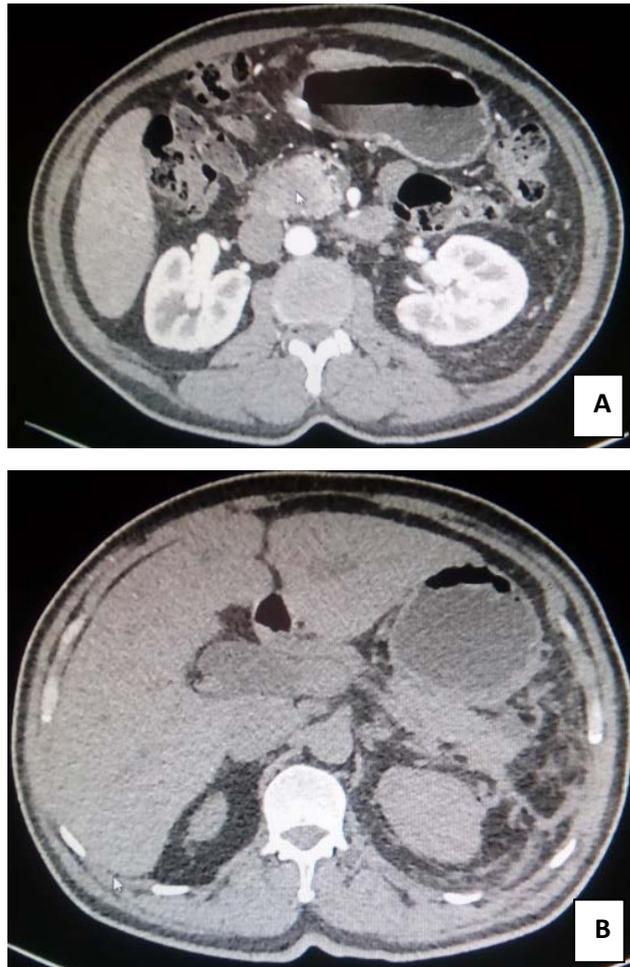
Repeat CT imaging of the abdomen revealing a hypovascular mass 2.7x3.3x2.4cm in the head of the pancreas (A) producing extrinsic compression of the distal common bile duct. There are hypovascular masses noted in the tail of the pancreas (B) suggestive of multiple abscess versus malignancy. There were no enlarged periaortic, interaortocaval or mesenteric lymphadenopathies.
